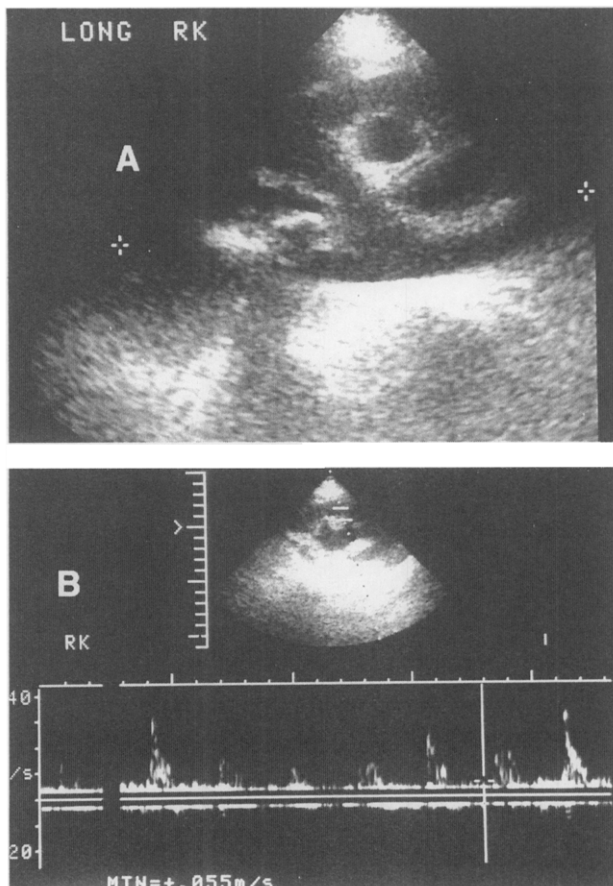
Case 1. (A) Isolated image from right renal ultrasound showing moderate dilatation of collecting systems. Incidental note is made of upper pole calculus (poorly visualized). (B) Doppler profile shows resistive index calculated from this image was 0.88, compatible with obstruction rather than passive dilatation.
